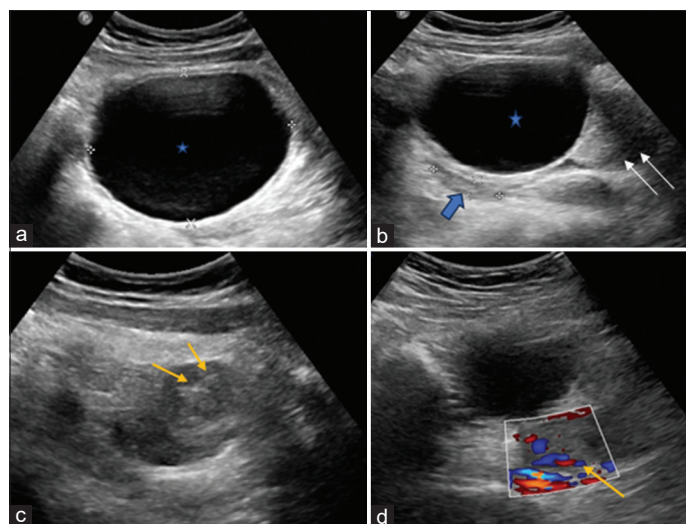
Ultrasonographic image revealing- (a) A thin-walled cystic lesion (asterisk) in the midline arising from left adnexa with few dependent internal echoes. (b) The enlarged left ovary (arrows) was seen abutting the lesion. Possible para ovarian/exophytic ovarian cyst was considered. (c and d) a whirl-like echogenic lesion in left adnexa (arrows) with minimal peripheral vascularity - whirlpool sign s/o twisted pedicle
